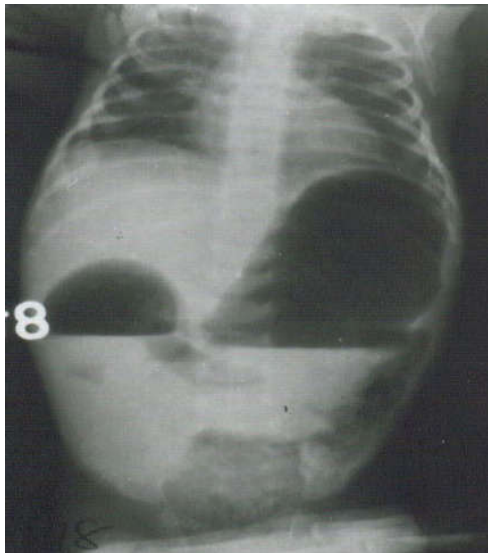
Plain x-ray abdomen showing "double bubble" sign.
